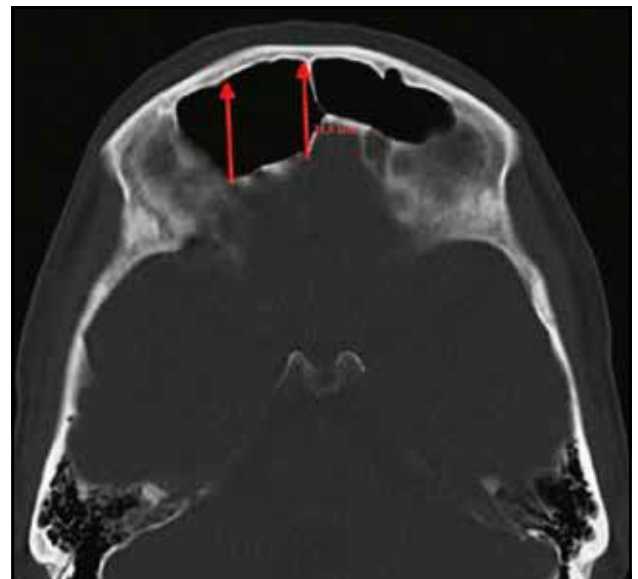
Cranio-facial native CT scan – axial section, revealing right frontal sinus enlargement, beyond the maximum limits (anteroposterior length – 21.5 mm), without any modifications of the bone or the mucosa.
